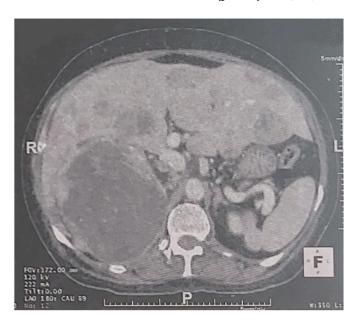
CT showing right renal pelvis tumor locally advanced with diffuse hepatic metastasis.
